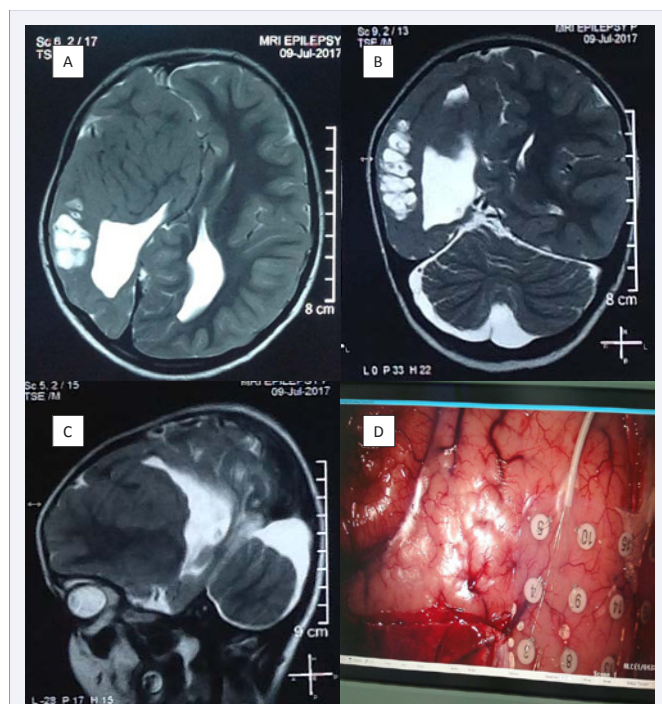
Preop Axial (A) Coronal (B) and Sagittal (C) MRI images of the child showing extensive gliosis and polymicrogyria. Intraoperative electrocorticography-ECoG (D).
